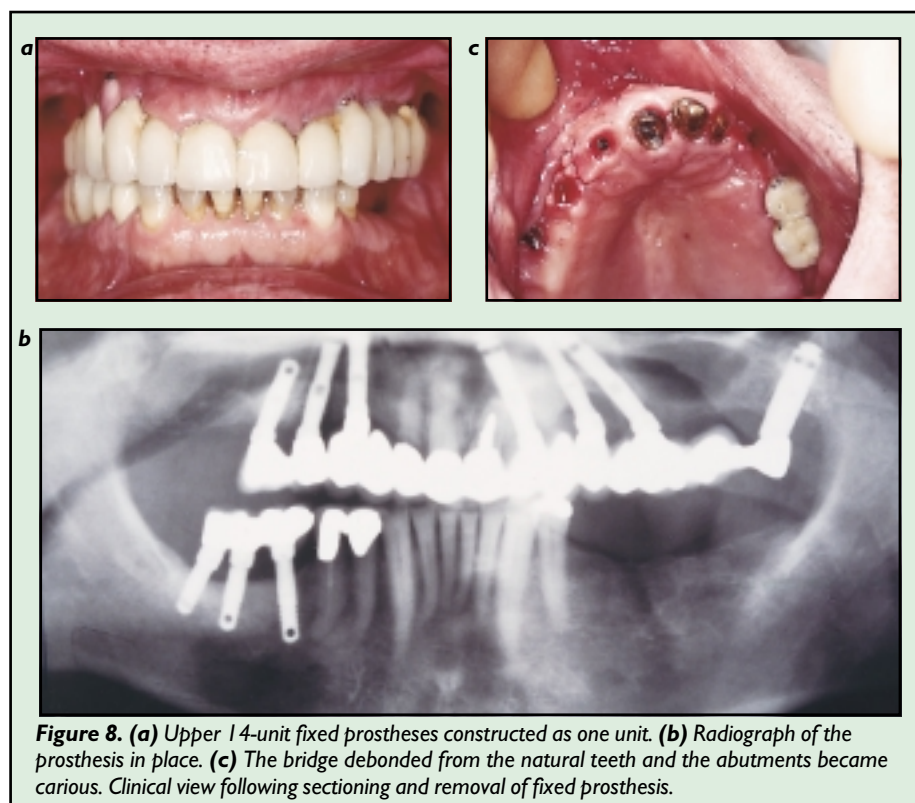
(a) Upper 14-unit fixed prosthesis constructed as one unit. (b) Radiograph of the prosthesis in place. (c) The bridge debonded from the natural teeth and the abutments became carious. Clinical view following sectioning and removal of fixed prosthesis.
